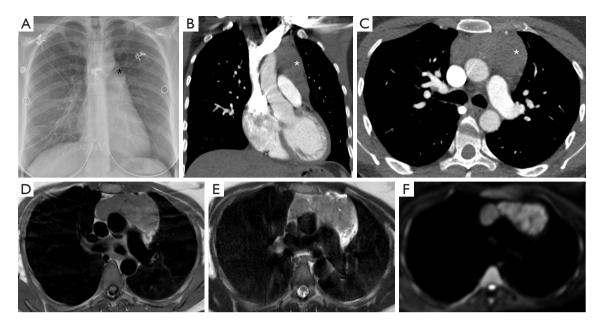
Hodgkin's lymphoma imaging with different radiographic modalities. (A) Frontal chest radiograph shows a mass in the anteriorposterior window (*). (B,C) Coronal and axial contrast-enhancing chest CT show a corresponding homogeneous, lobulated soft tissue mass (*) in the anterior mediastinum, which abuts the superior vena cava, aorta, and main pulmonary artery. The mass demonstrates (D) T1 isoto hyperintensity on T1-weighted axial magnetic resonance imaging images, (E) heterogeneous T2 hyperintensity on T2-weighted axial magnetic resonance imaging images, and (F) restricted diffusion on diffusion-weighted images with suggestion of septations. Subsequently, ultrasound-guided biopsy revealed Hodgkin lymphoma. CT, computed tomography.
